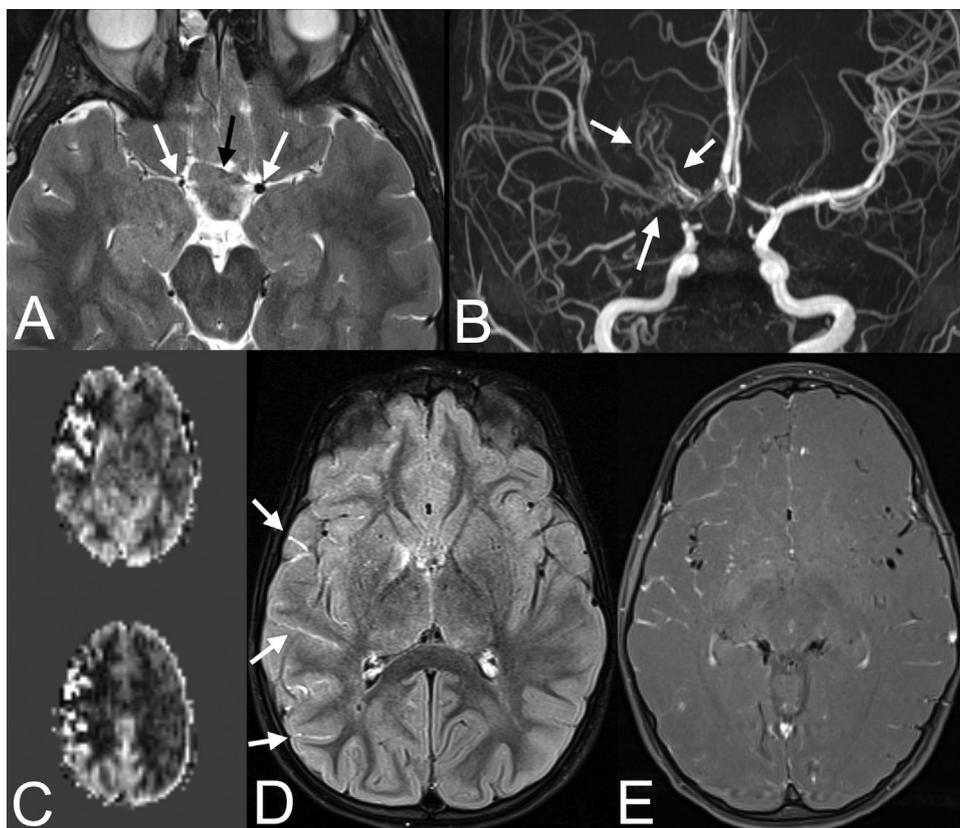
Various MRI manifestations of moyamoya syndrome in neurofibromatosis type 1. (A) Axial T2-weighted image shows asymmetric narrowing of the flow void of the right distal intracranial internal carotid artery compared with the left (white arrows). The patient's chiasmatic glioma is also seen (black arrow). (B) Time-of-flight magnetic resonance angiography more clearly shows the marked narrowing of the distal right internal carotid artery and parts of the right middle cerebral artery (MCA) and the anterior cerebral arteries. There is development of extensive collateral vessels in the MCA cistern and basal ganglia lenticulostriate vasculature (white arrows). (C) Arterial spin labeling (ASL) perfusion imaging shows delayed arterial transit in the right MCA branches. (D) Axial fluid-attenuated inversion recovery (FLAIR) image shows high signal in the sulcal vessels due to slower flow (FLAIR ivy sign, white arrows). (E) Axial postcontrast T1-weighted image shows asymmetric contrast enhancement of the right-sided sulcal vessels, also due to slower flow.
